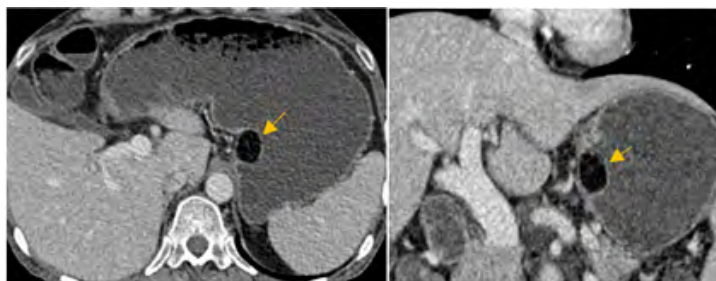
Abdominal CT scan after injection of contrast at port time in axial and coronal section: gastric parietal lesion, rounded, hypodense of fat density (-90 HU) with a thin capsule .
